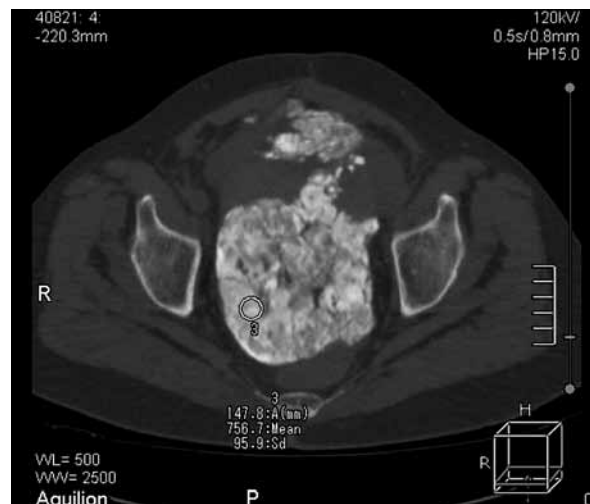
Reconstruction of volumetric computed tomography of the abdomen with a visible calcium deposit in the abdomen
